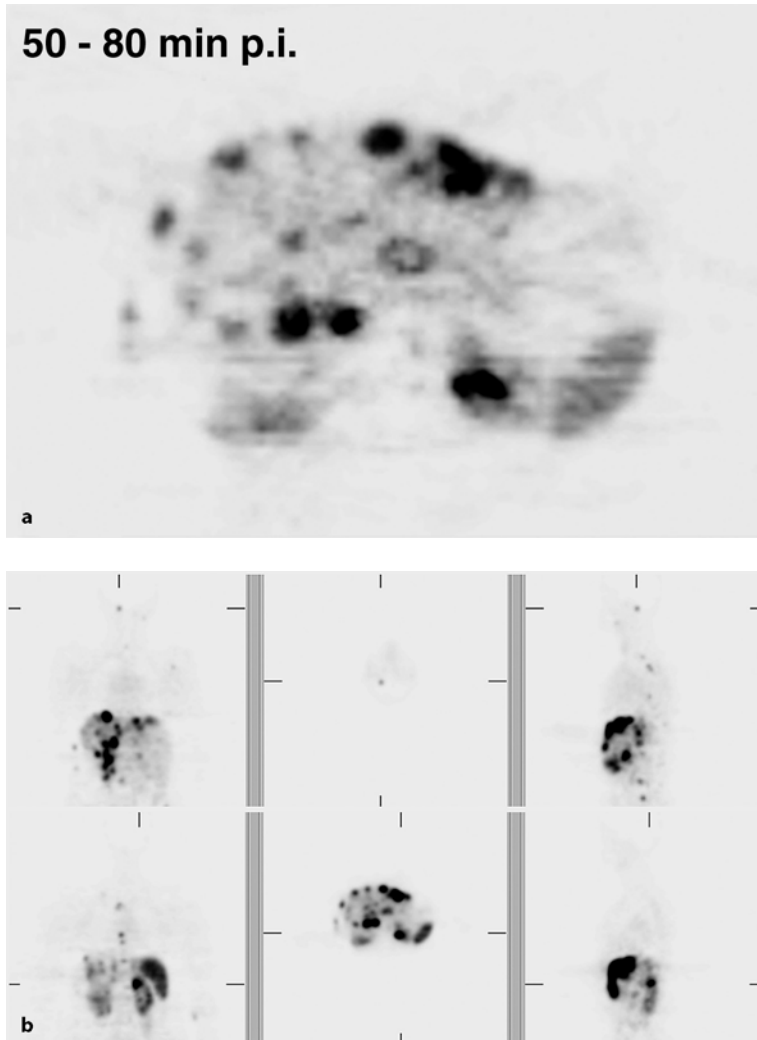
a UPT: neuroendocrine tumor, ^{68}Ga -DOTATOC PET; multiple liver metastases: minimum \varnothing 5 mm, SUV 24.7. b UPT: neuroendocrine tumor, ^{68}Ga -DOTATOC PET; previously unknown metastases
